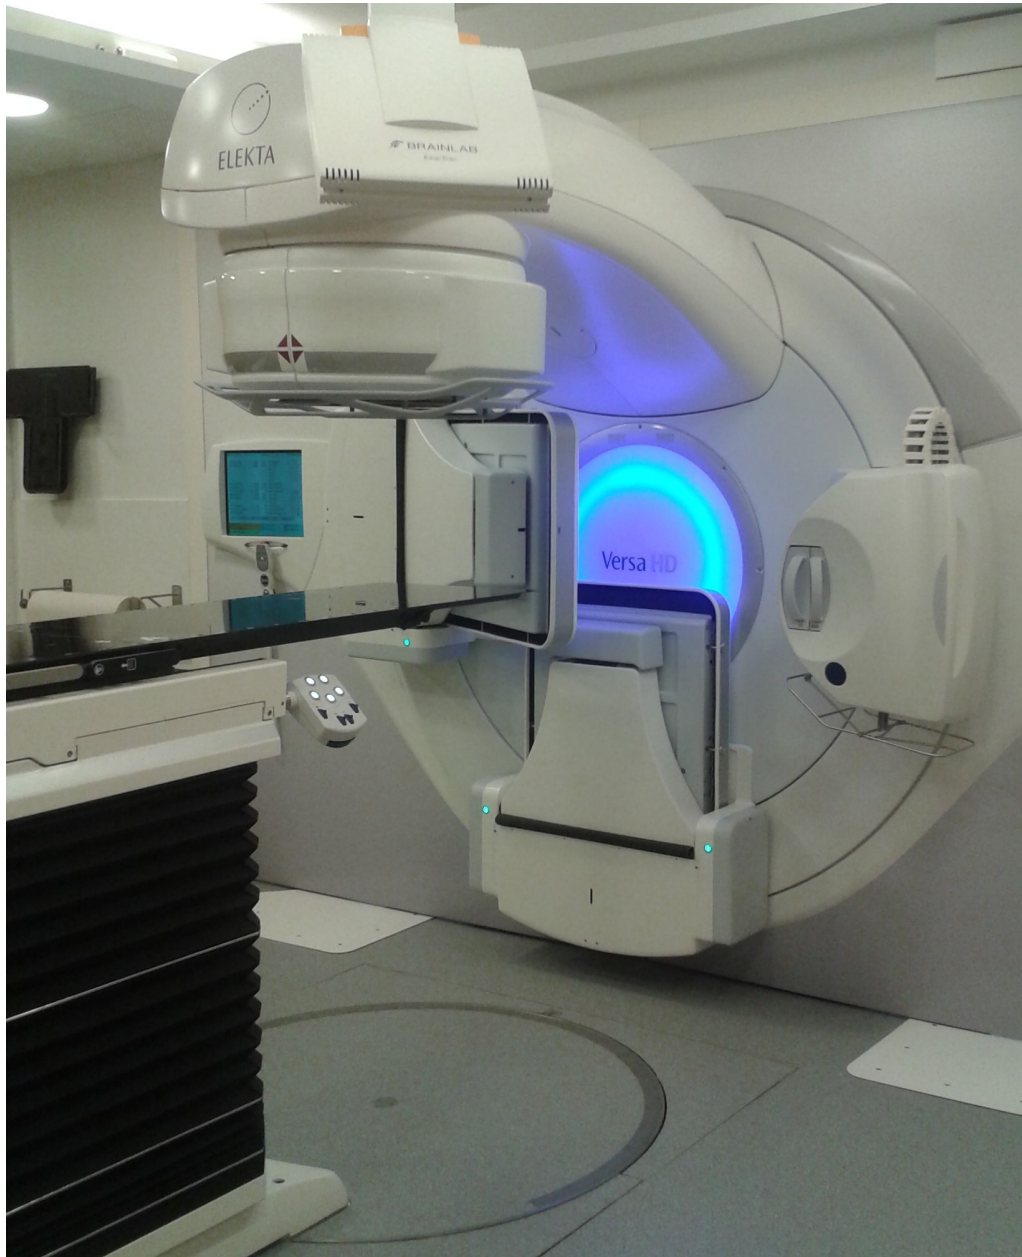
A linear accelerator with an isocentric set-up, Elekta Versa HD in HUCH. The gantry of the linac rotates a whole circle around the isocentre. The treatment table can also be moved and rotates around the vertical axis going through the isocentre. Opposite to the gantry there is a flat panel MV radiation detector for MV imaging. On the right there is an X-ray tube and on the left there is a detector for kV imaging. The imaging equipment is turned off the way of the treatment radiation.
